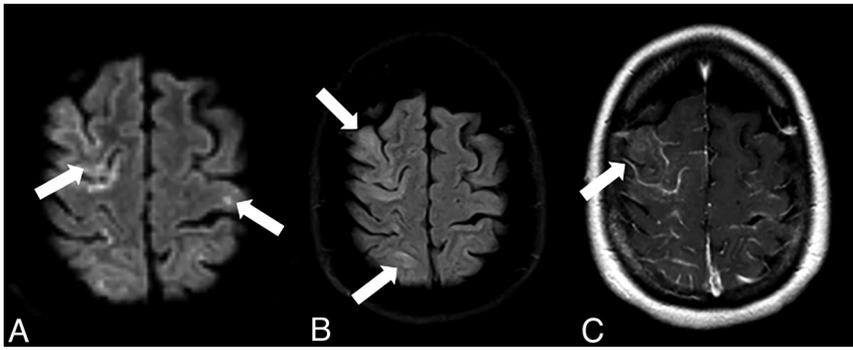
Contrast-enhanced brain MRI in a 68-year-old man with suspected CAE revealing a mixed pattern of cytotoxic (*white arrows*, DWI sequence, A) and vasogenic edema (*white arrows*, T2-FLAIR sequence, B) in a distal vascular bed distribution, with associated leptomeningeal enhancement adjacent to regions of edema (*white arrow*, postcontrast [MultiHance; Bracco Diagnostics] 3D gradient-echo T1 sequence, C).
